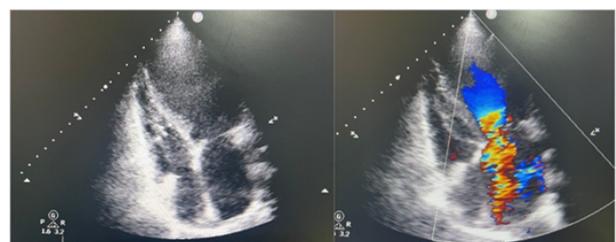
Echocardiography demonstrated moderate mitral regurgitation and left atrial enlargement
